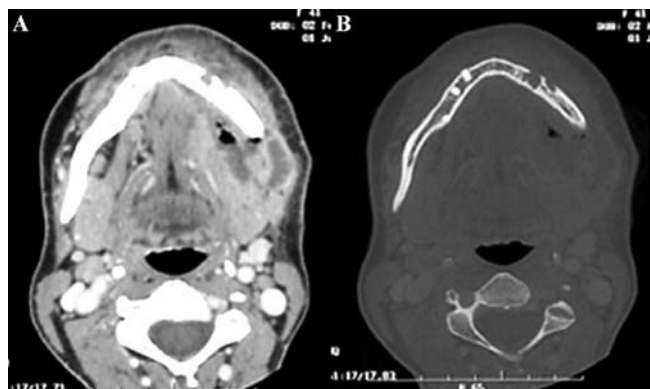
A 41-year-old female affected by an odontogenic abscess in left MS, seen as a non homogeneous hypodense mass located within muscles of mastication (A), correctly diagnosed by CT. The origin of the infection from a fistulizing paradental socket was clearly identified using CT bone window (B).
